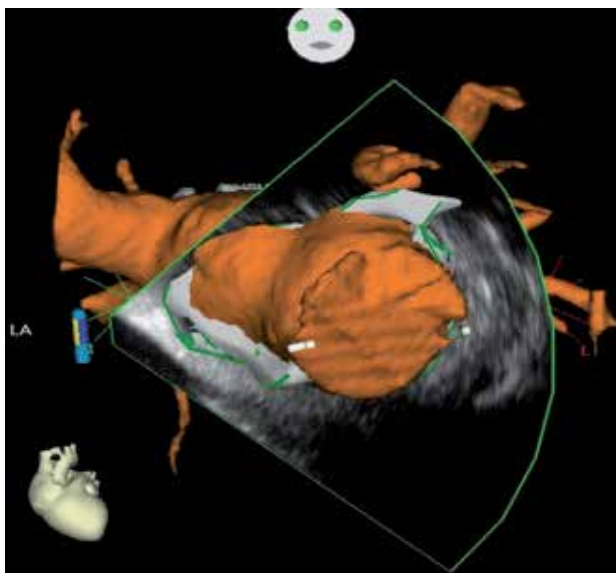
The CARTOSound mapping technology that fused ultrasound images into the reconstructed volume. Image taken from Knecht et al., 2008. (doi: 10.1093/europace/eun227)
